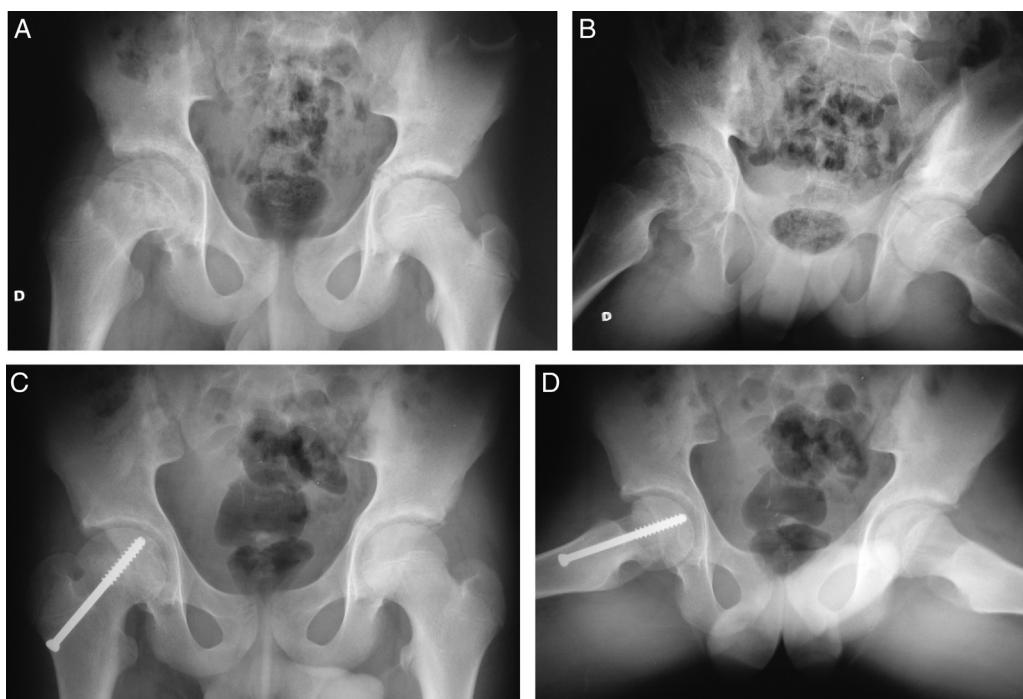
Male patient aged 11 years. Pain in the right hip for two months, was able to walk without crutches. Hip locked in IR, 80° of flexion. (A) and (B) Preoperative radiographs showing Southwick grade II SCFE on the right, EDA 54° . (C) and (D) Postoperative radiographs at 20 months of follow-up showing the correction of the deformity, EDA 8° .
